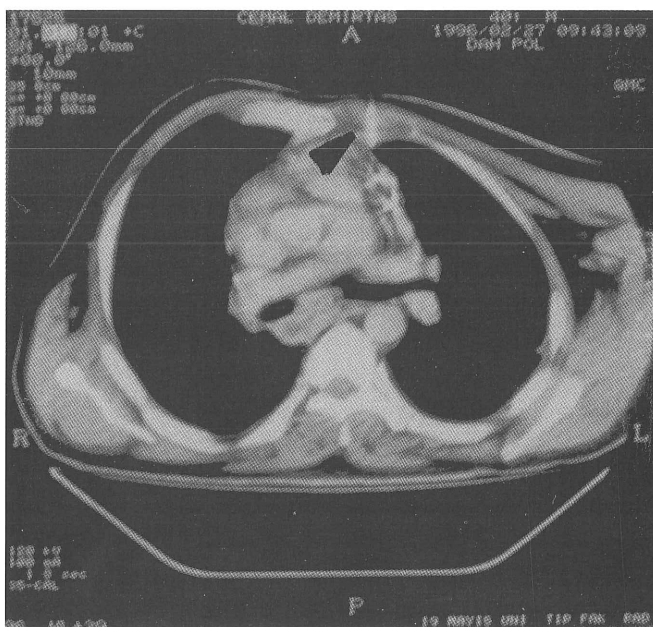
Thorax computed tomography section showing the catheter (arrow) placed into the mediastinal cysts.
